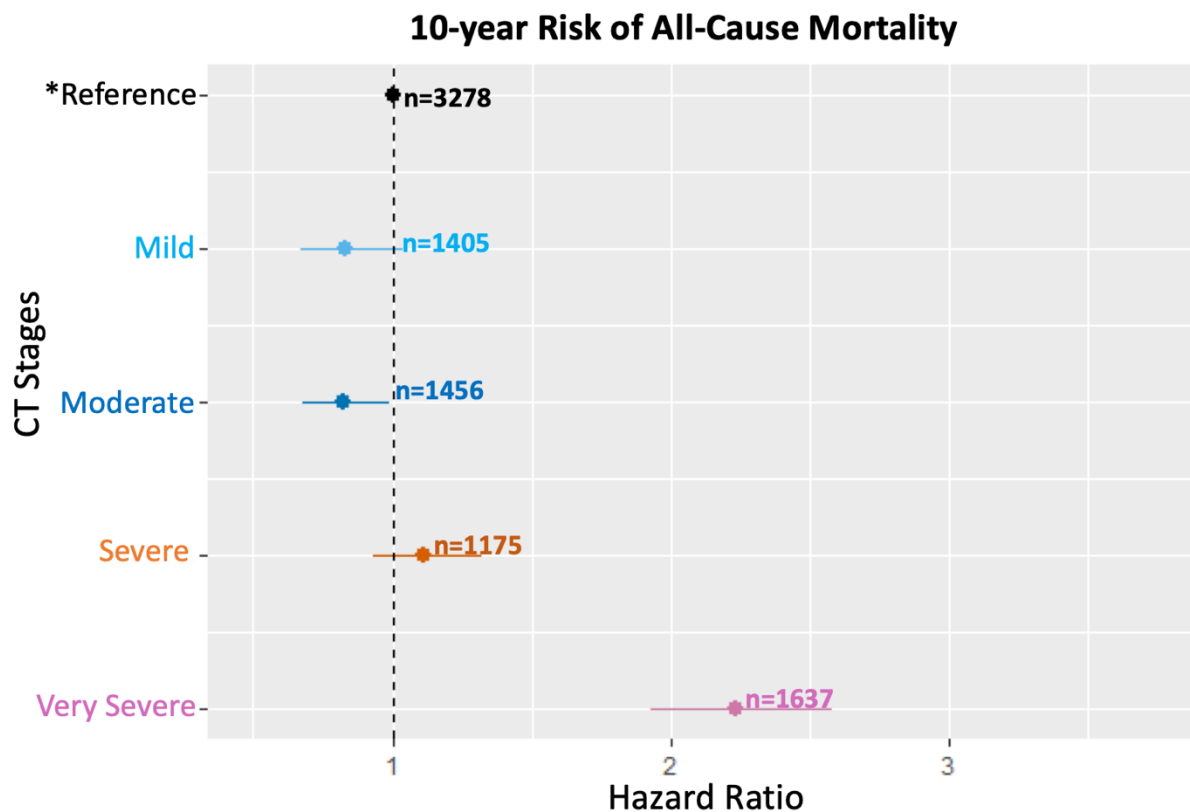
Patients who have very severe disease on CT also have significantly greater risk of mortality in 10 years.
